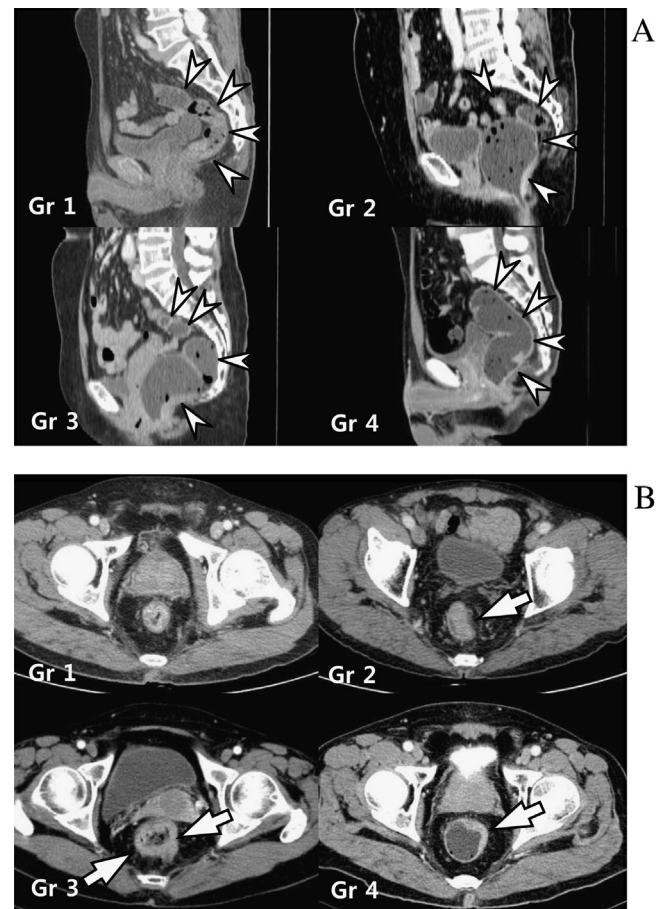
Semi-quantitative grading for the degree of rectum distention (A) and tumor visualization (B) on CT images. (A) Grading for the degree of rectum distention on sagittal CT images. Grade 1 is defined as when the entire rectum (arrowheads) is collapsed; grade 2 when the rectum (arrowheads) is partially distended with more than one collapsed segment; grade 3 when the rectum (arrowheads) is suboptimally distended with one collapsed segment; grade 4 when the entire rectum (arrowheads) is fully distended without a collapsed segment. (B) Grading for the degree of tumor visualization on axial CT images. Grade 1 is defined as when the tumor could not be identified; grade 2 when the tumor (arrow) is identified but its intraluminal margin is not defined; grade 3 when the tumor (arrows) is identified and its intraluminal margin is partially defined; grade 4 when the whole tumor margin (arrow) is well defined.
